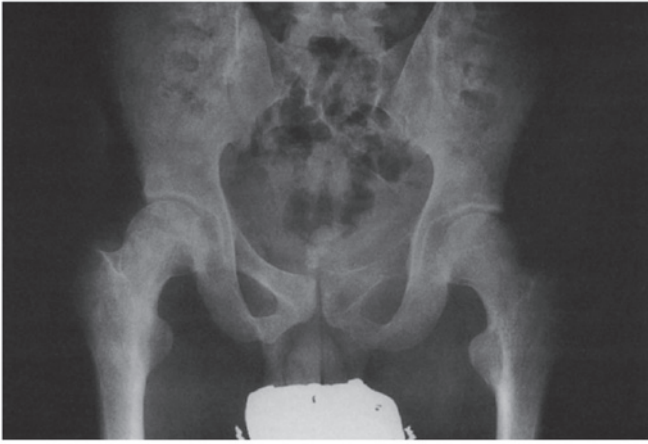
Plain radiograph revealing a lytic mass involving the left pubis, ischium and acetabulum.
